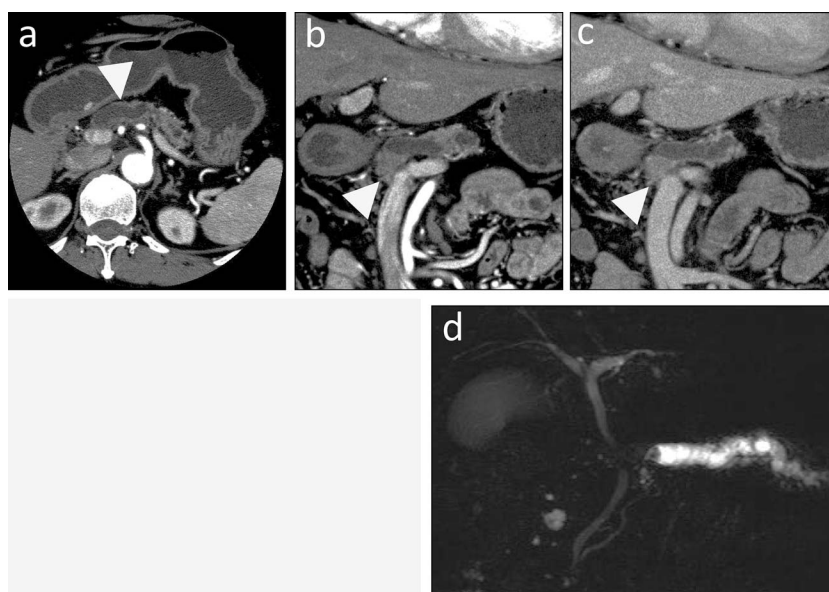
Abdominal CT and MRCP. (a) CT revealed dilatation of the main pancreatic duct in the region of the body and tail of the pancreas (arrowhead). (b, c) A mass lesion (arrowhead) is seen in the head, which showed persistent enhancement after administration of contrast material. (d) MRCP revealed interruption of the main pancreatic duct at the tumor site, and beaded dilatation of the duct in the region of the body and tail of the pancreas.
